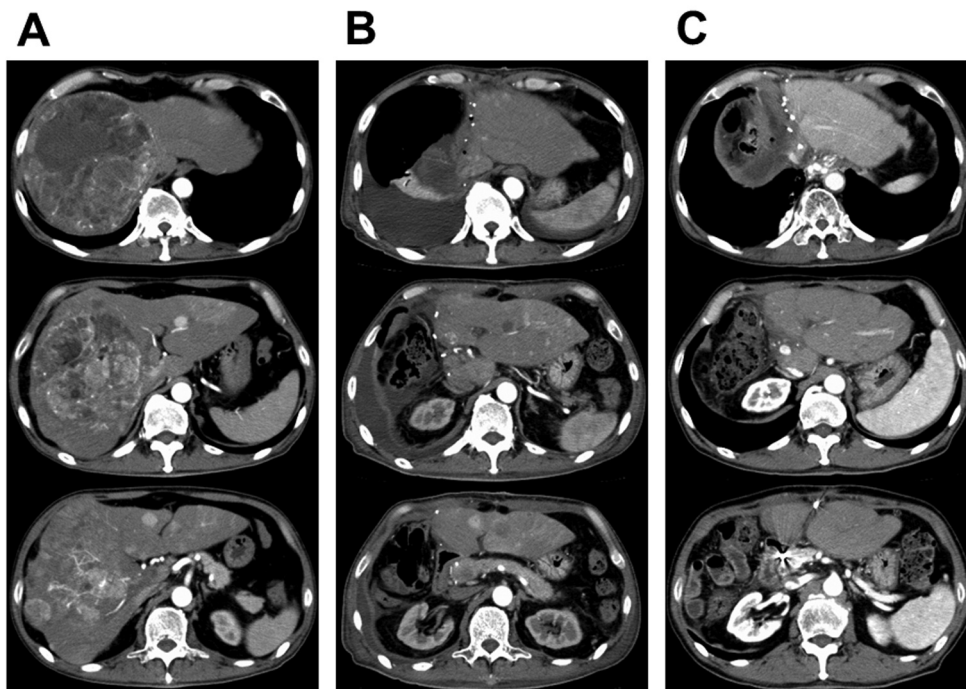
The representative case after reductive hepatectomy and subsequent local treatments. (A) Preoperative contrast-enhanced computed tomography shows multiple tumors. (B) Postoperative contrast-enhanced computed tomography shows residual tumors after right lobe hepatectomy. (C) Post-percutaneous isolated hepatic perfusion (PIHP) contrast-enhanced computed tomography shows the complete response after PIHP.
